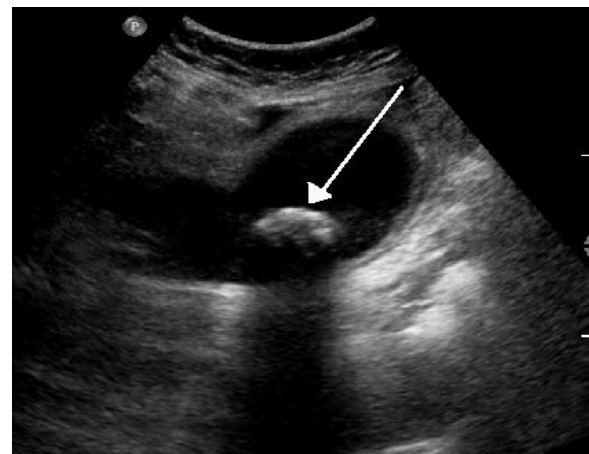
1 Gallstone 2.1 cm impacted in the neck of the gallbladder and leading to cholecystitis as seen on Ultrasound, There is 4 mm gall bladder wall thickening.
